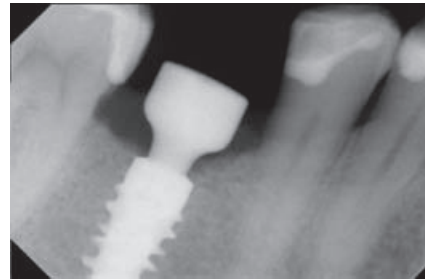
Periapical X-Ray immediately after implant placement before crown seating.
